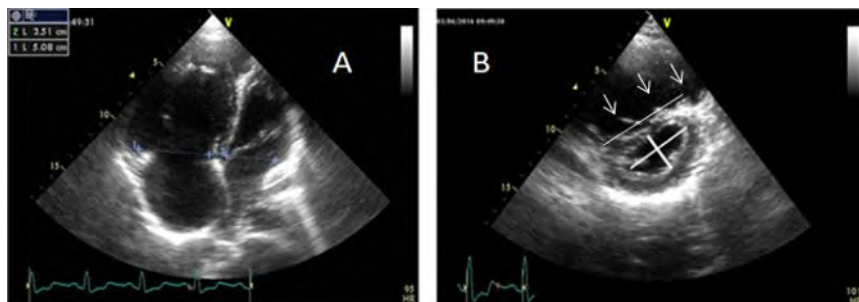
Transthoracic echocardiography of (A) four-chamber view showing that the right ventricle is bigger than the left ventricle, and the ratio RV/LV is bigger than 1; (B) Parasternal short axis at the level of the papillary muscles showing dilated right ventricle with flattening of the interventricular septum (D-shape of the left ventricle) and index of the eccentricity of the left ventricle bigger than 1.
